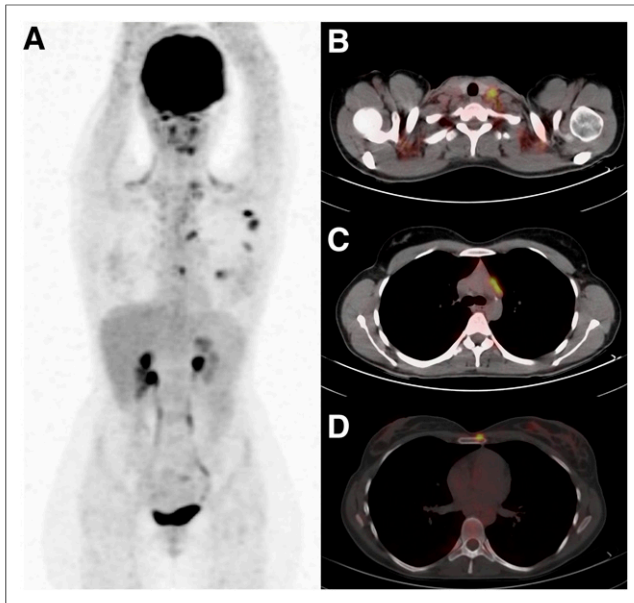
^{18}F -FDG PET/CT at initial staging in 35-y-old patient with invasive ductal carcinoma of left breast, classified as clinical stage IIA disease. (A) Maximum-intensity projection. (B–D) Axial PET/CT fusion images showing cervical (B) and mediastinal (C) lymph node and bone (D) metastases.
